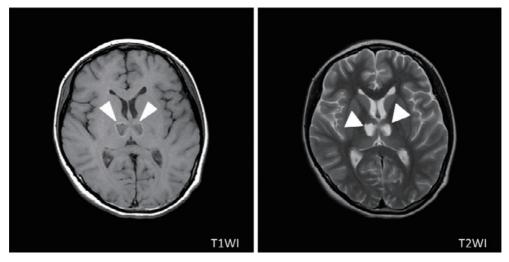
Brain MRI on the 19th day of illness showed bilateral symmetric lesions in the thalamus that were hyperintense on T2-weighted and fluid-attenuated inversion recovery images (arrowheads).
